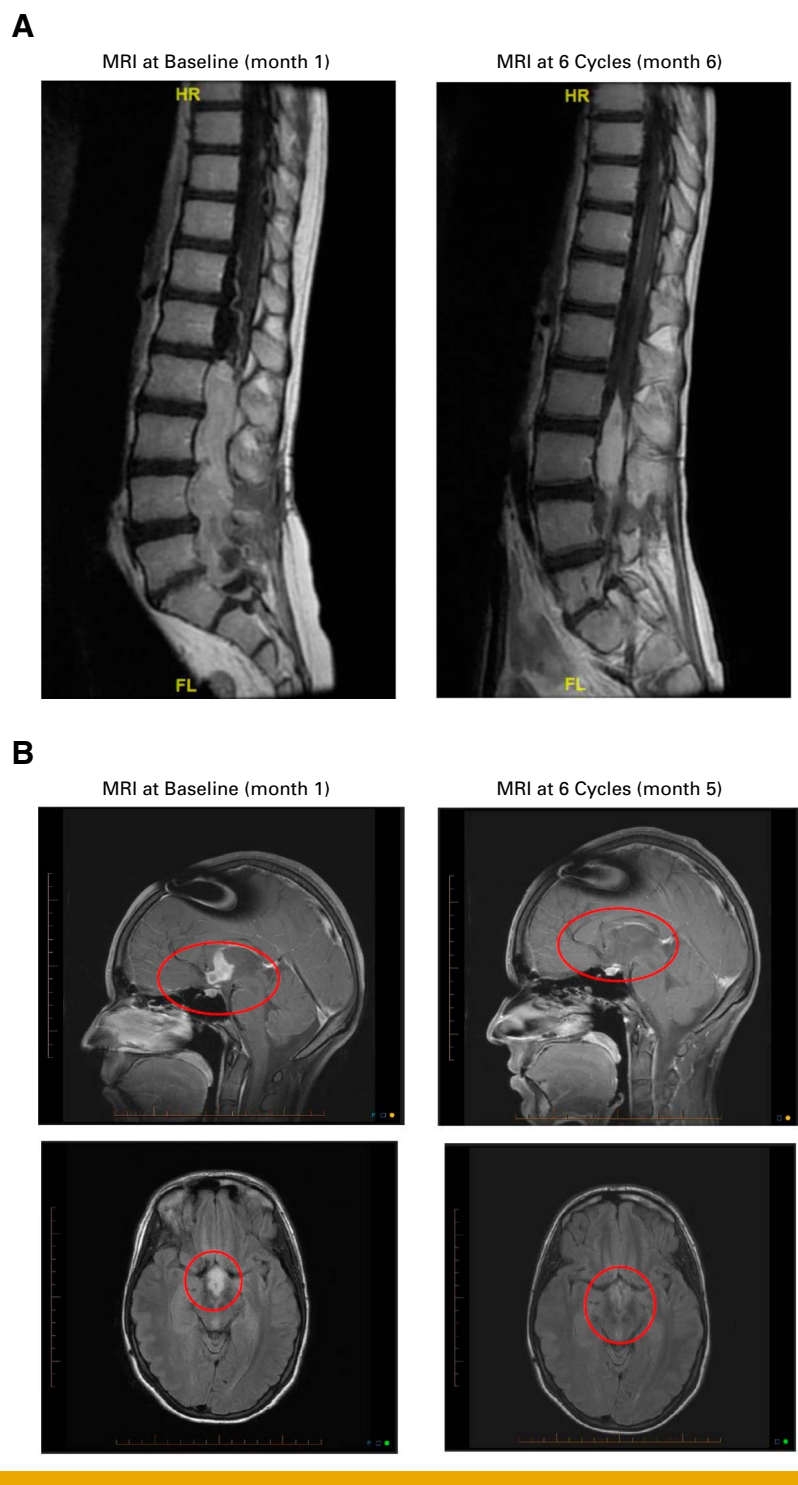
(A) Case study of a 26-year-old patient with dysembryoplastic neuroepithelial tumor and a *FGFR1*-K656E mutation who achieved a complete response for 21.68 months and (B) case study of a 13-year-old patient with anaplastic pilocytic astrocytoma and a *FGFR1*-TACC1 fusion who achieved a partial response of 19.75 months. MRI, magnetic resonance imaging.
